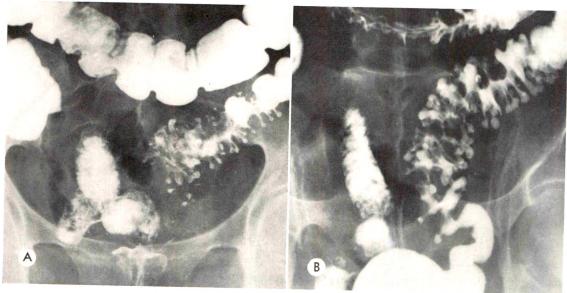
Roentgenograms showing diverticulosis with evidence of old diverticulitis. (A) Anteroposterior view. (B) Angled view.
